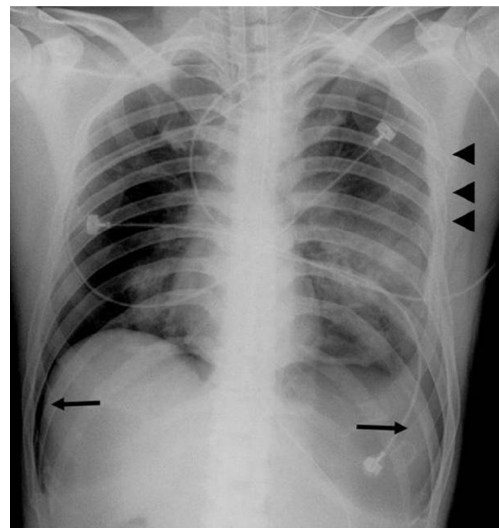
Supine chest radiography shows bilateral deep sulcus signs (arrows) and multiple rib fractures (arrowheads).
